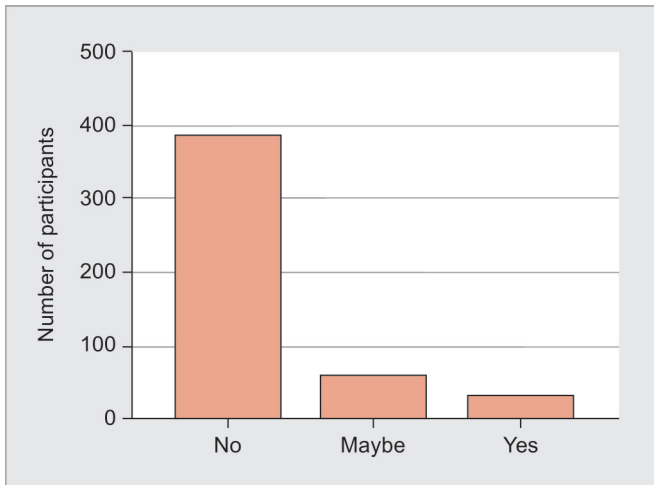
CBCT and high risk of radiation exposure
